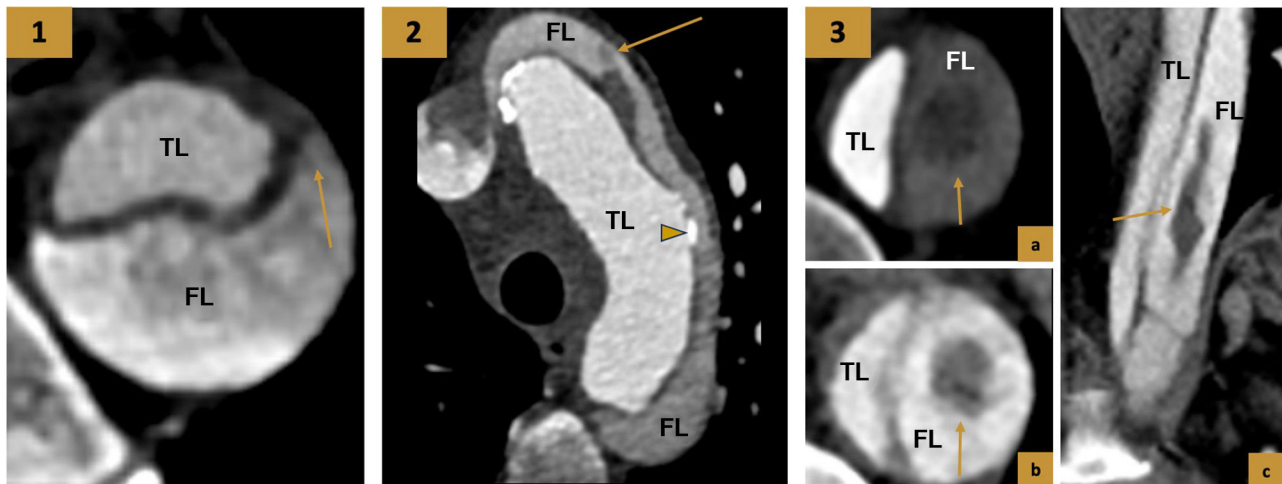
Characteristics to differentiate the two lumens. (1) Peak sign. Contrast-enhanced CT in arterial phase, axial slice. The intimal *flap* forms an acute angle with the external wall of the false lumen (arrow). (2) Contrast-enhanced CT in arterial phase, axial slice. Cobweb sign and intimal calcifications. Linear low attenuation band (arrow) inside false lumen representing torn medial layer fragments. Intimal calcifications displaced into the lumen and on the external wall of the true lumen (arrowhead). (3) Thrombus formation in the false lumen. (a and b) CT in early and late arterial phases, axial slices. Filling defect within the false lumen that persists into the late arterial phase and confirms the presence of thrombus. (c) Contrast-enhanced CT in the late arterial phase, coronal slice. The elongated linear filling defect is identified in association with partial thrombosis of the false lumen.
